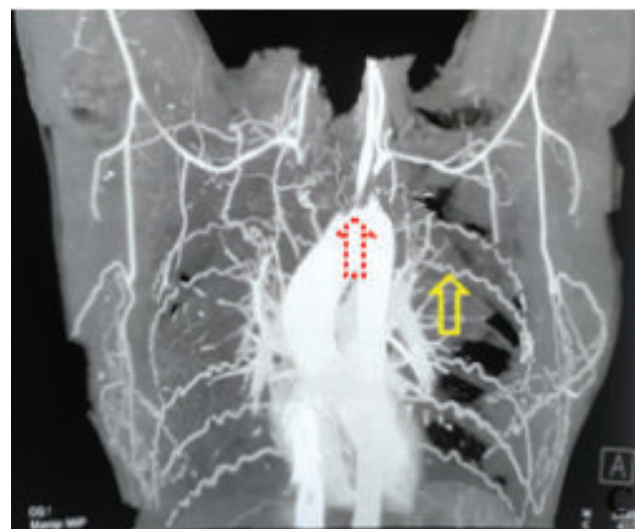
CT-angiogram showing narrowing of three great vessels near origin and multiple collaterals.
